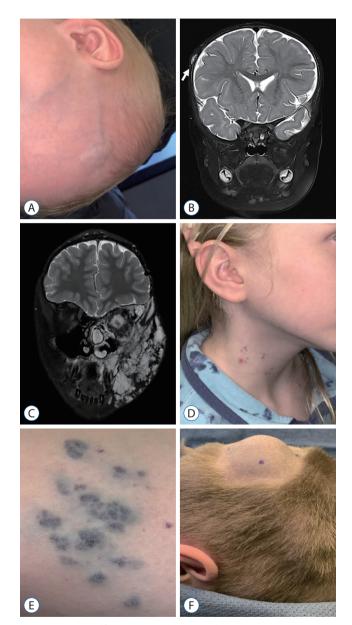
Venous malformation can have varied cutaneous appearance. A : Venous malformation of the right forehead is engorged when patient held in dependent position. The coronal T2 magnetic resonance imaging (MRI) shows hyperintense signal (B, arrow). C : A T2 MRI shows a large venous malformation of the left face and neck with similar T2 hyperintensity over a much larger region. D : A glomuvenous malformation is visible on the neck. E : Cutaneous appearance of venous malformation. F : An engorged venous malformation associated with sinus pericranii in this intraoperative view of the occipital region in a patient positioned prone with the hair clipped.
